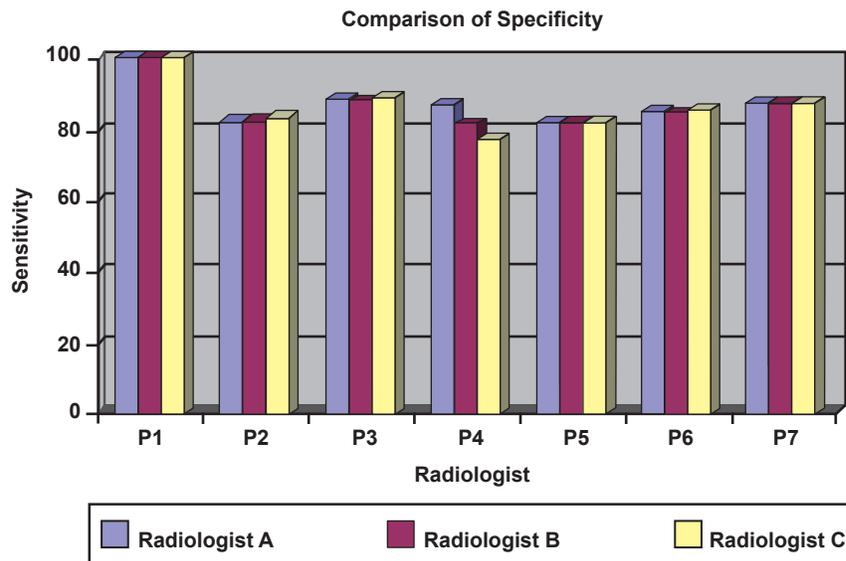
Comparison of the specificity of the different CT predictors
